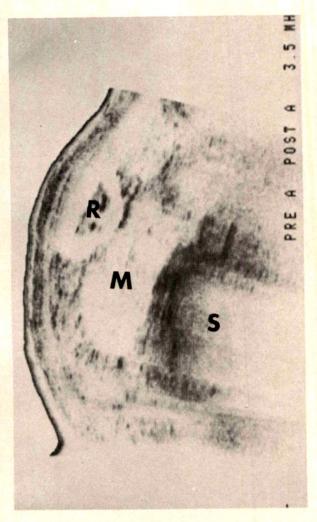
Left lateral decubitus sonogram through the right midabdomen. The right kidney (R) is displaced laterally from the spine (S) by a fluid-filled mass (M).
